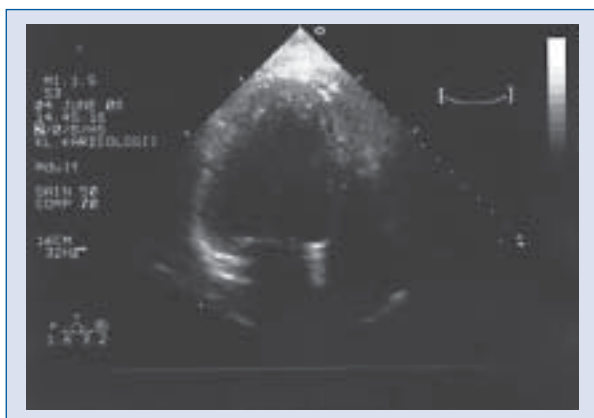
Apical four-chamber projection in patient showing dilated cardiomyopathy and incorrect shape of the left ventricle.
